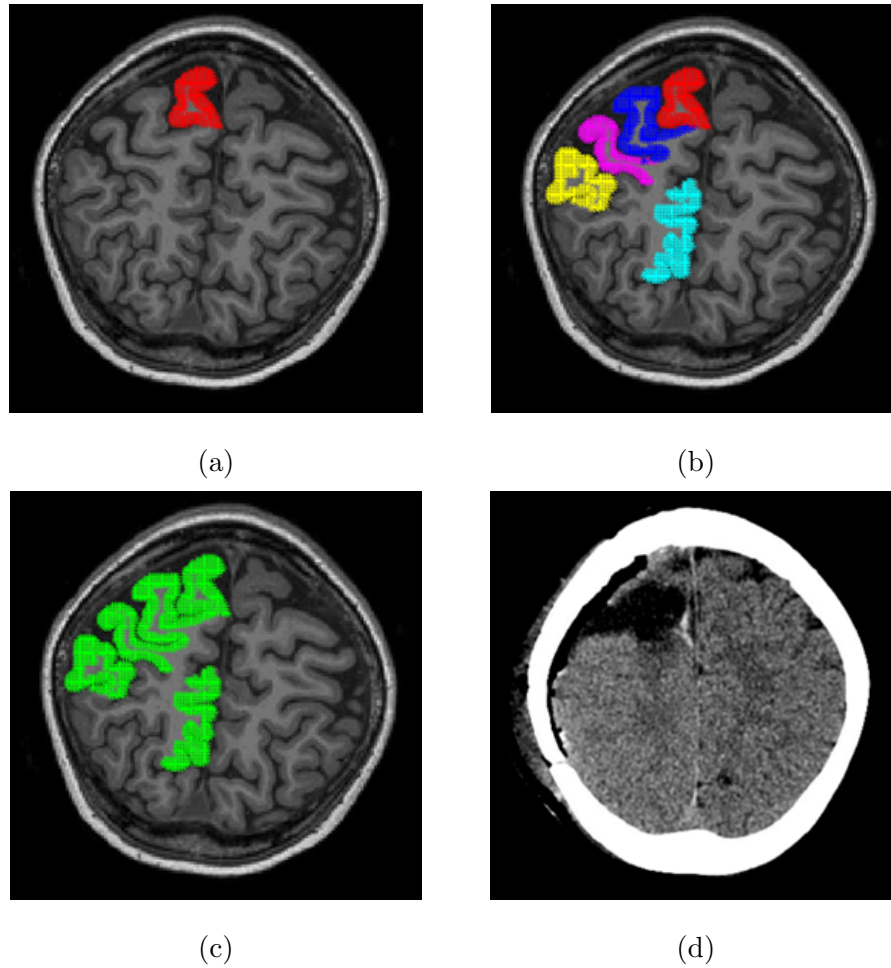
Results of the true lesion structural location of NL043 and the selected structures. (a) Displays select T1 axial slice with corresponding FreeSurfer region (rightsuperiorfrontal) of lesion highlighted in red. (b) Select T1 axial slice with selected FreeSurfer regions using 2-Step Naive Bayes classification method with colours differing on the basis of region selected (magenta - rightpostcentral, blue - rightprecentral, cyan - rightpre-cuneus, red - rightsuperiorfrontal, Yellow - rightsupramarginal). (c) Select T1 axial slice with selected FreeSurfer regions using 2-Step Naive Bayes Classification method with all selected structures in green. (d) Associated post-surgical CT scan displaying resected location.
